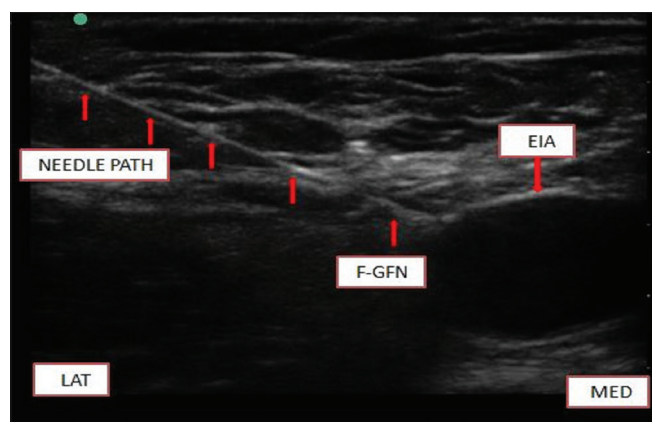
Ultrasonographic image showing needle path from lateral to medial side with needle tip adjacent to the femoral branch of genitofemoral nerve. F-GFN: Femoral branch of genitofemoral nerve, EIA: External Iliac Artery, MED: medial side, LAT: Lateral side
